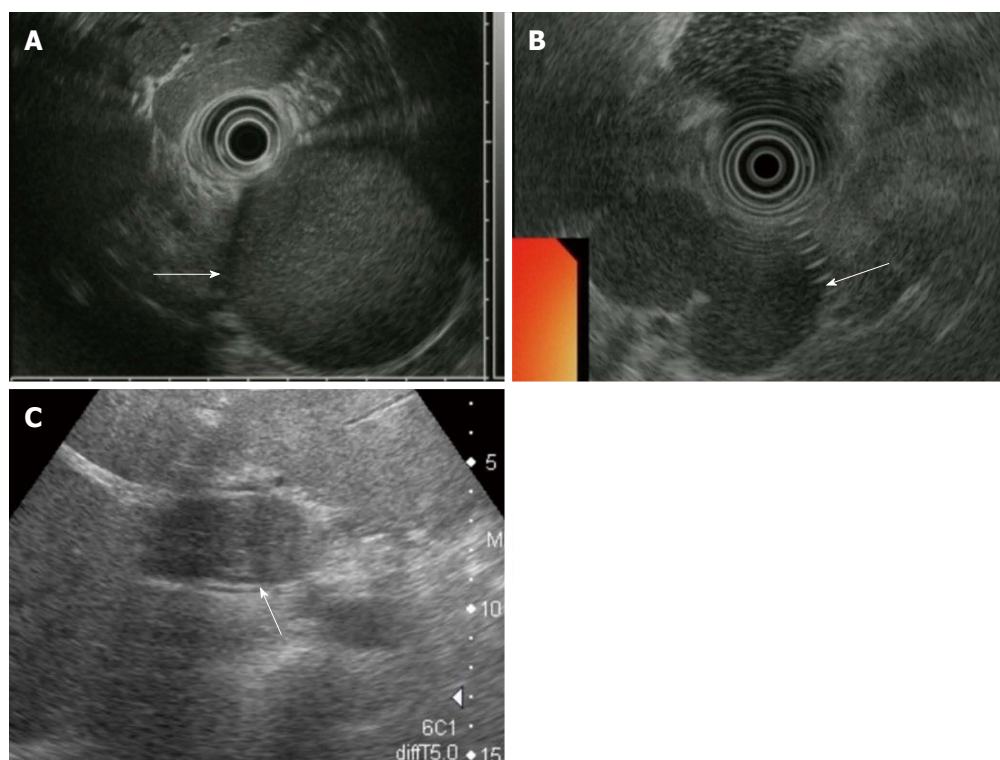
Ultrasonography and endoscopic ultrasonography findings. A: Findings of Patient #2, the cystic lesion had a hyperechoic appearance (arrow); B: Findings of Patient #3, the cystic lesion had a homogenous hypoechoic appearance (arrow); C: Findings of Patient #4, the cystic lesion displayed a mosaic pattern (arrow).
